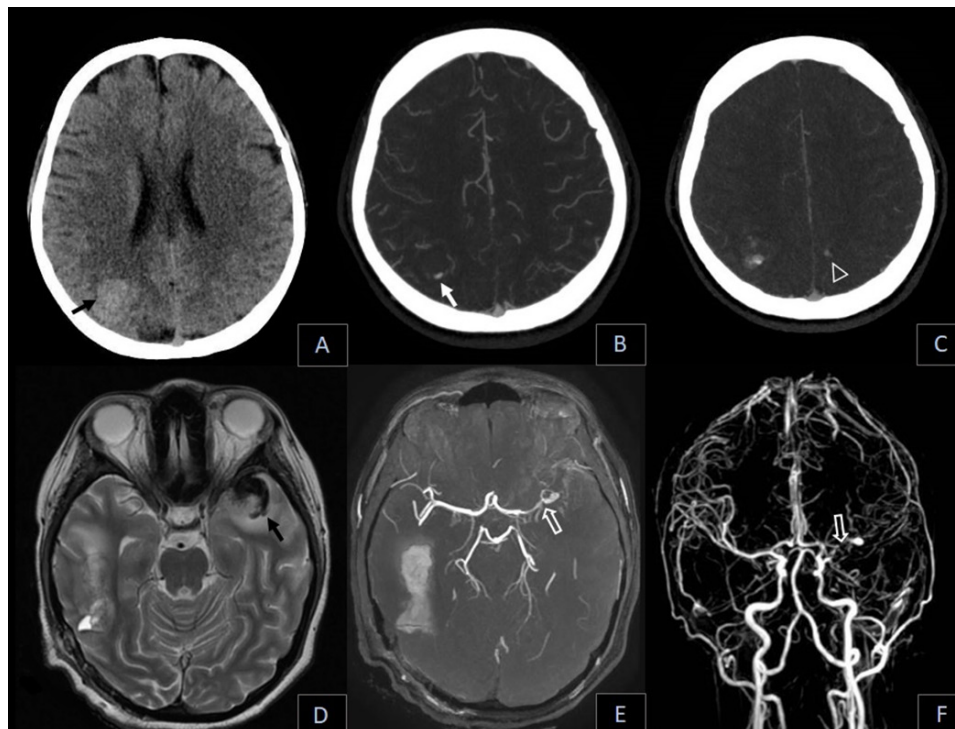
A 20-year-old-female with moderate to severe mitral regurgitation and a 0.8x0.3-cm oscillating mass at the posterior mitral valve leaflet. Axial CT brain (A) demonstrates subacute intraparenchymal hematoma in the right parietal lobe (black arrow). Further CT angiography (B) shows a small aneurysm in the right parietal area (solid white arrow). Axial delayed phase CT angiography (C) shows increased contrast accumulation surrounding the right parietal aneurysm and a new small nodular contrast pooling in left parietal lobe (open white arrowhead), suspicious of mycotic aneurysms with hemorrhage and contrast extravasation. The patient underwent follow-up MRI after craniotomy and hematoma removal ten days afterward. The axial T2-weighted image (D) shows new intraparenchymal hematoma in the left anterior temporal lobe (black arrow). Axial MIP time-of-flight MRA (E) and contrast enhanced MRA (F) demonstrate new severe stenosis of the proximal M1 segment of the left MCA and a saccular aneurysm distal to the luminal stenosis (open white arrows).
